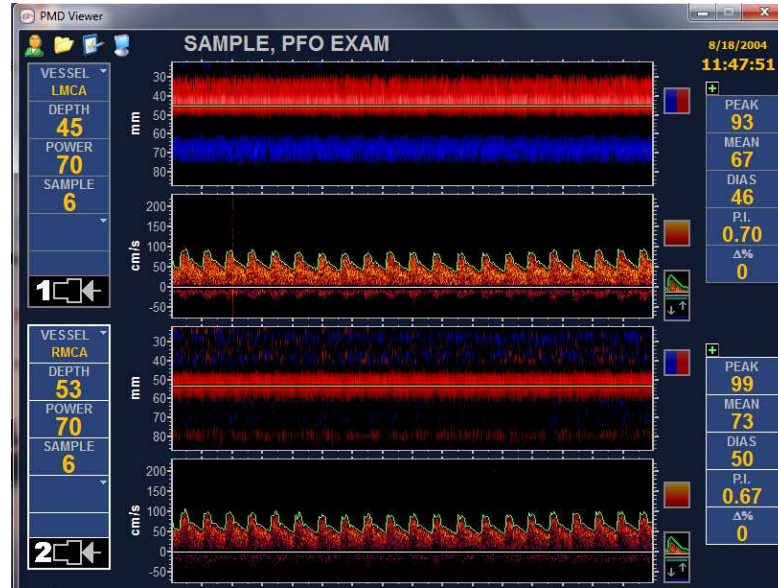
Power M-mode Doppler [17].
